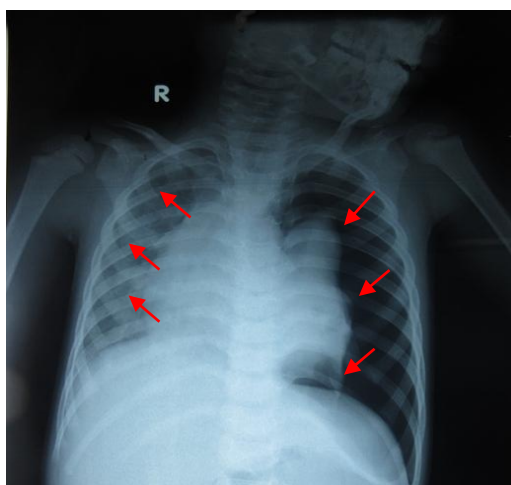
Chest radiography of the patient showed bilateral pneumothorax with air in bilateral pleural spaces (arrow).
